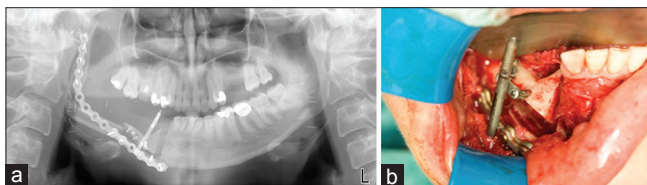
(a) Orthopantomograph of the distractor intraorally fitted on the Uni-Lock reconstruction plate (b) Fixation of the custom-made distractor on the Uni-Lock plate
